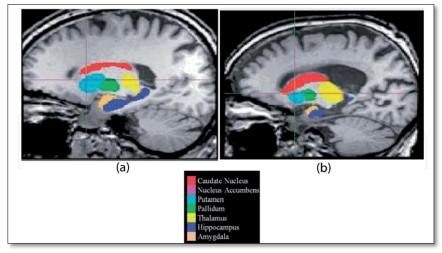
Sub cortical segmentation of MRI scans, after boundary correction, of (a) a subject classified as MCI, (b) and of a subject diagnosed with probable Alzheimer's disease [62].
